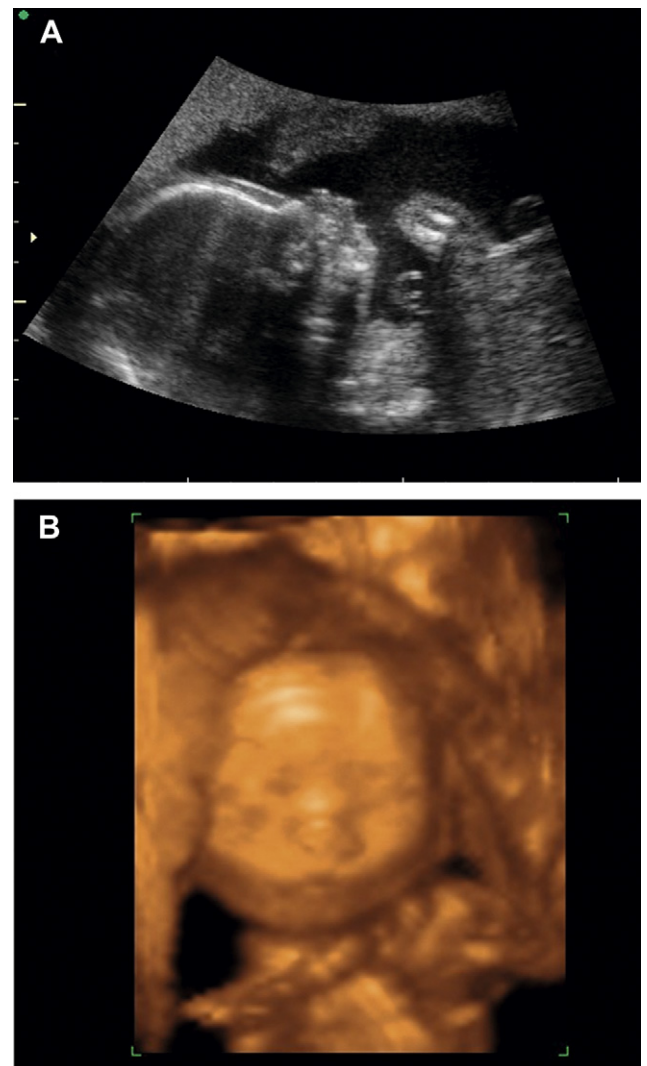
(A) Two-dimensional and (B) three-dimensional ultrasound demonstration of midface hypoplasia and micrognathia.
